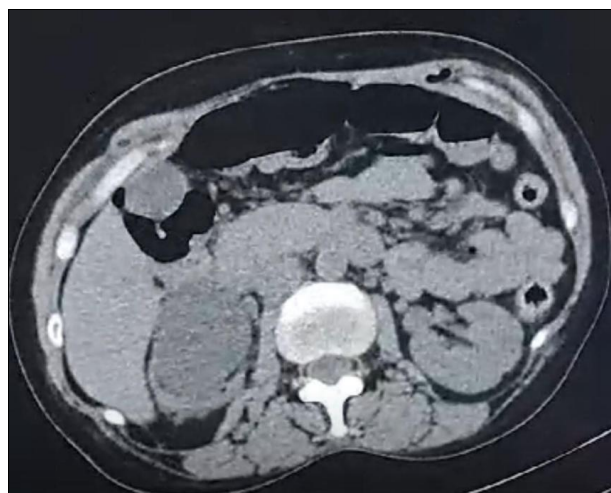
Showing Axial CT section demonstrating bilateral duplex ureters, with moderate dilatation of the lower moiety of the right kidney, while the upper moiety appears normal
